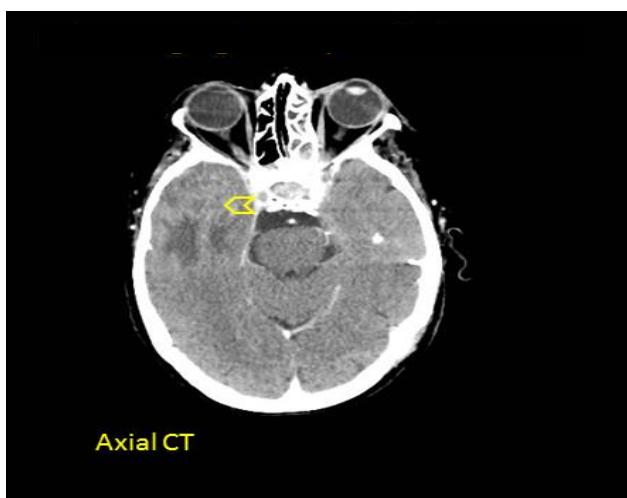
Axial CT Enhancing right temporal lobe mass.
